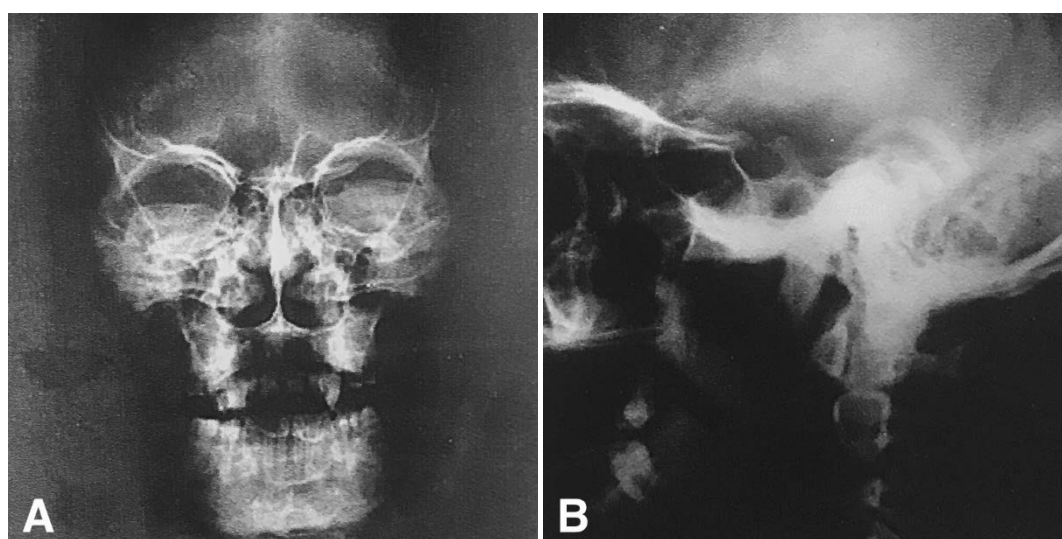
Plain radiography performed after bullet evacuation through a laminectomy. No signs of bullet fragments were found on the: A) anterior view; B) Lateral view.
